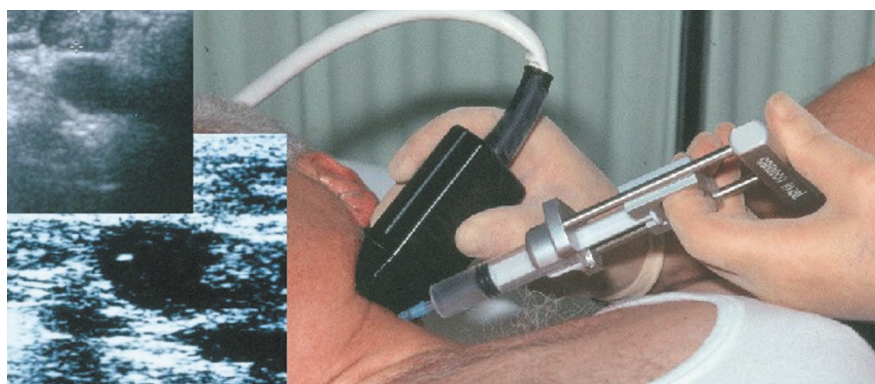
Ultrasound guided fine needle aspiration cytology of enlarged lymph nodes in the neck
